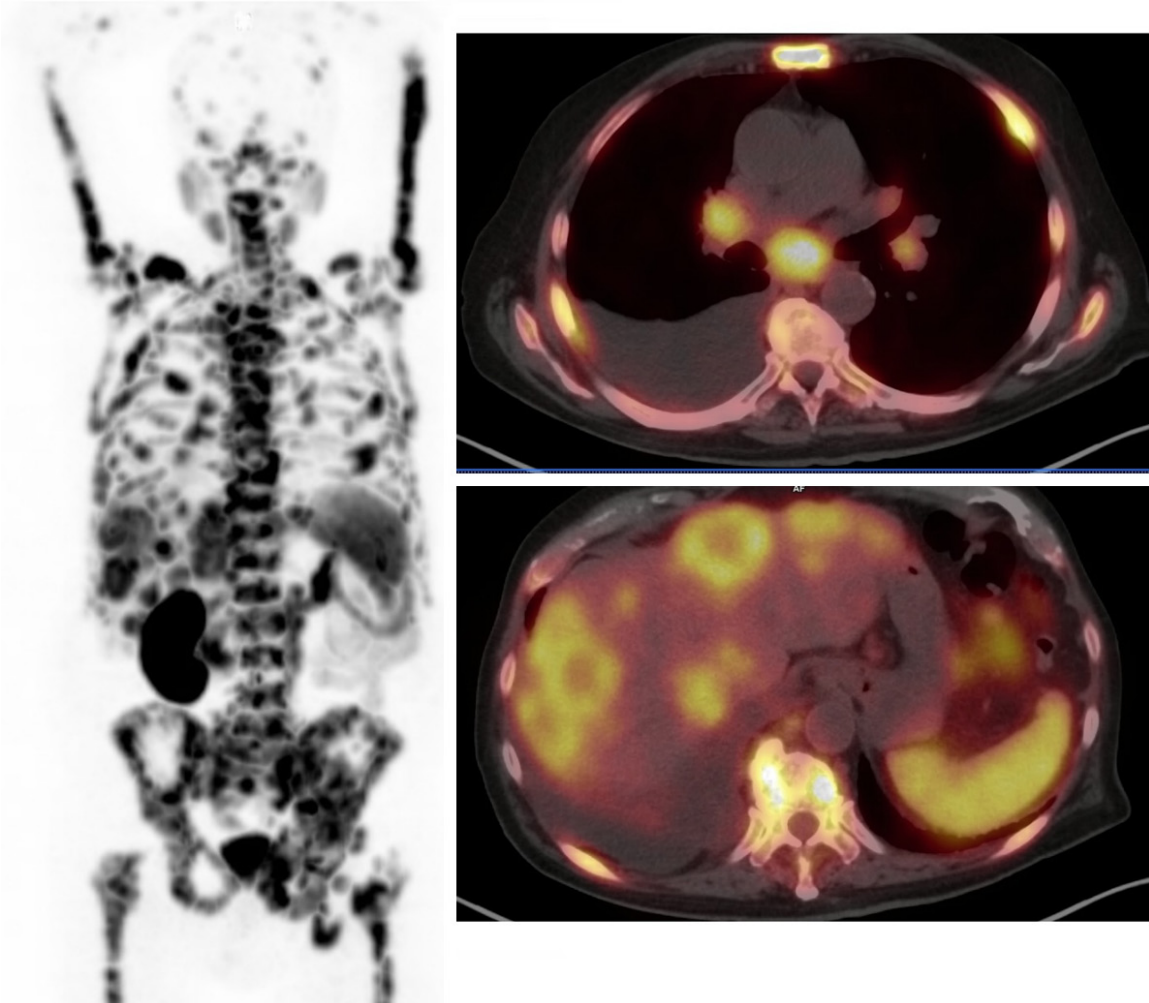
A. Baseline <sup>18</sup>F-Fluoride PET/CT scan demonstrates bone metastases in the spine, scapulae, sternum, ribs bilaterally, and pelvic bones. During treatment, the patient developed signs of progression. B. A <sup>68</sup>Ga-PSMA PET/CT scan demonstrated overexpression of PSMA receptors in similar sites as the <sup>18</sup>F-Fluoride PET/CT and the left supraclavicular, mediastinal, and hepatic hilar lymph nodes. Because of soft tissue lesions, the patient was treated with Ra-223 concomitant with secondary hormonal therapy and responded well to treatment.
